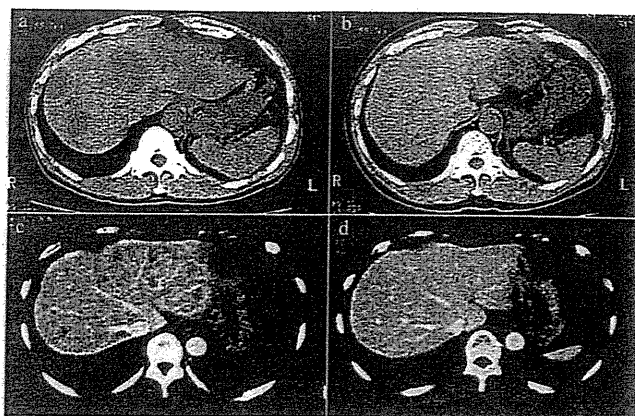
Abdominal computed tomography of 2 patients. a,b Case 1: multiple liver metastases a before treatment, and b after treatment when no metastases could be detected; c,d Case 2: multiple liver metastases c before treatment, and d after treatment when no metastases could be detected.
